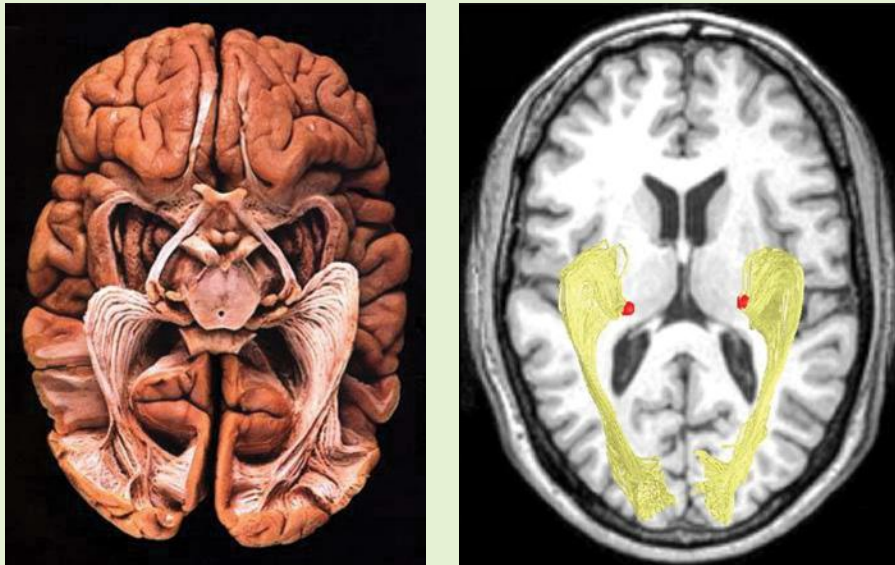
Image on left shows a human brain dissected to reveal the pathways from retina, via LGN, to V1. Particularly striking are the elegant optic radiations, the myelinated fibers running between the thalamus and the primary visual cortex. To expose these pathways and structures, the anatomist dissected away tissue from the ventral surface of the brain, up to and including the ventral bank of the calcarine fissure. Thus, only the dorsal bank of the calcarine and the fibers of the optic radiations that project to it are seen here. (Some of this will make better sense after having read the first section of *Chapter 3*.) The image on the right shows a slice from a T1-weighted anatomical MR scan (grayscale) oriented to include both the LGN (pseudocolored red) and the calcarine sulcus. Superimposed, in yellow, is an image of the path of the optic radiations as estimated via MR-derived diffusion tensor imaging (DTI) tractography (see *Web Clip 2.1* and *Web Clip 2.2*). Source: Wandell and Winawer, 2011. Reproduced with permission of Elsevier.
